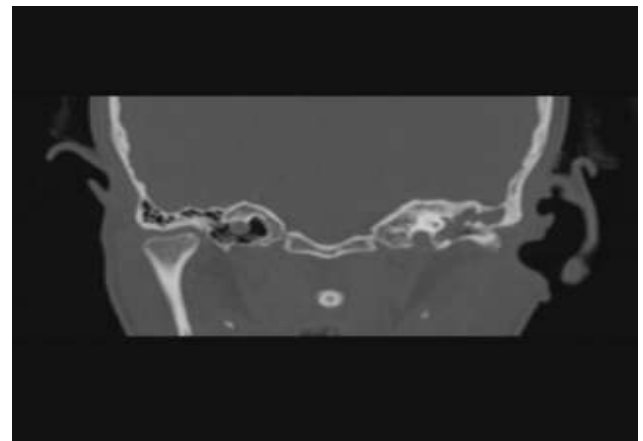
CT temporal bones, coronal view, demonstrating left otitis media
